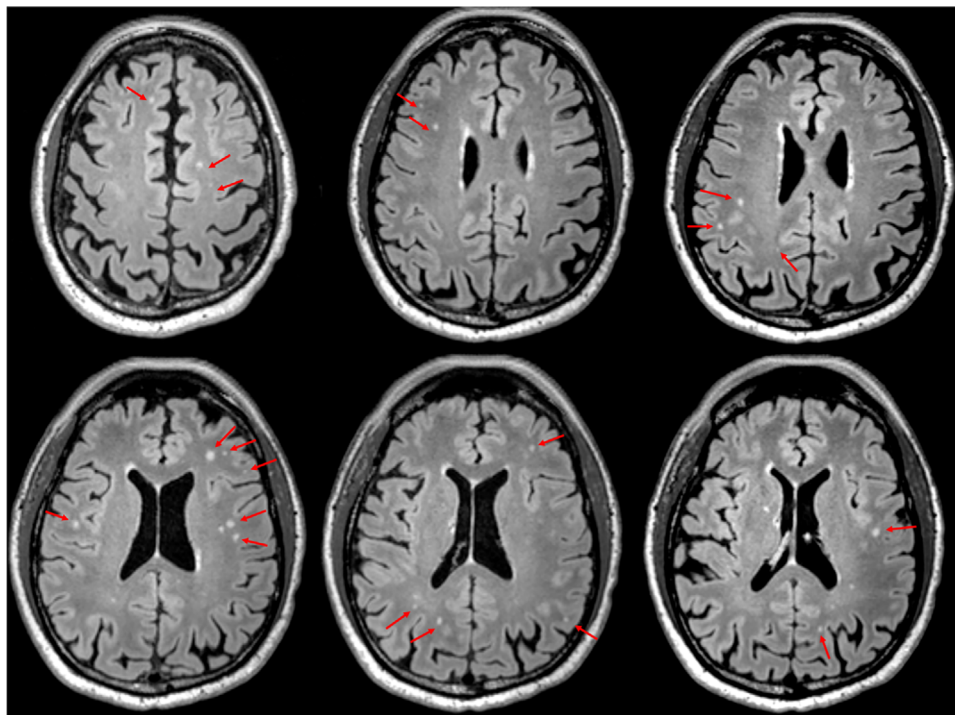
T2-FLAIR scan from a participant with substantial RHI exposure: Exemplar images of RHI-WMH. This figure, taken from Miner and Groh et al., displays the small, spherical punctate lesions close to the gray matter, distributed throughout the cortex, often in the absence of confluent periventricular lesions.²⁶ Lesions are also observed in relatively younger aged (e.g., 50s) individuals with minimal vascular risk factors. RHI, repetitive head impacts; T2-FLAIR, T2-weighted fluid-attenuated inversion recovery; WMH, white matter hyperintensities.
